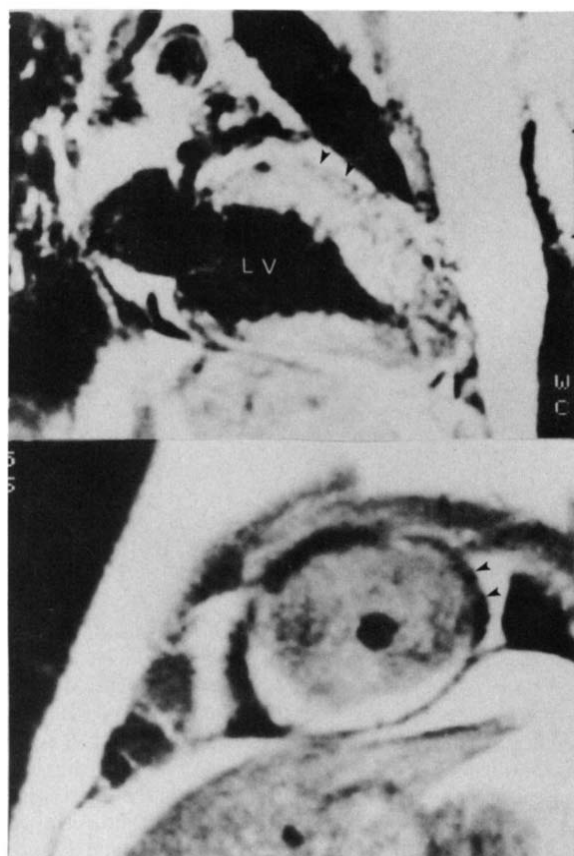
Nuclear magnetic resonance images from a patient with spade apical hypertrophic cardiomyopathy. Upper panel, Diastolic long-axis image corresponding to the left ventriculogram in the right anterior oblique projection that indicates a typical spadelike configuration. Lower panel, Short-axis image at the apical level that is obtained at end-diastole. Markedly and circumferentially hypertrophied myocardium is delineated. Arrowheads = pericardium. LV = left ventricle.
